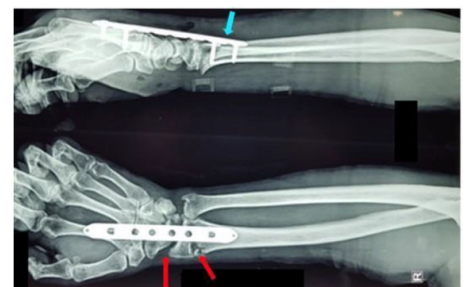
Post-operative right wrist PA/Lateral X-rays showing a nearly anatomical reduction of the radiocarpal joint using DBPF (blue arrow) with metaphyseal bone defect noted by the widening of radiocarpal joint space (the red arrows).
